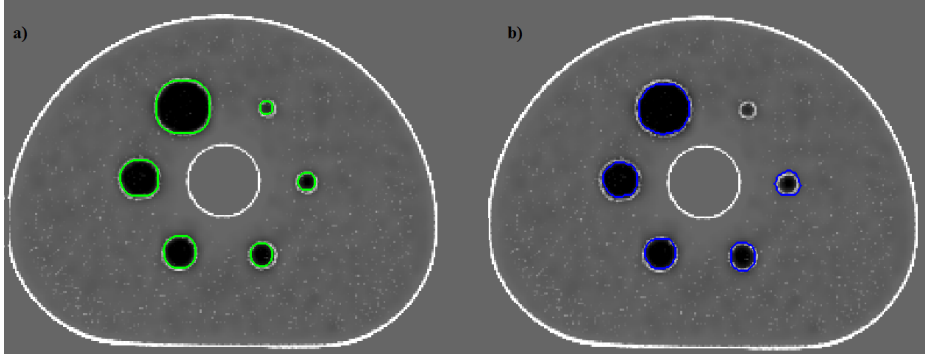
Segmentations of spheres showed in PET/CT image: (a) RWg DSC = 0.976 ± 0.023 (averaged on six spheres), (b) RG DSC = 0.918 ± 0.034 (averaged on five spheres)
